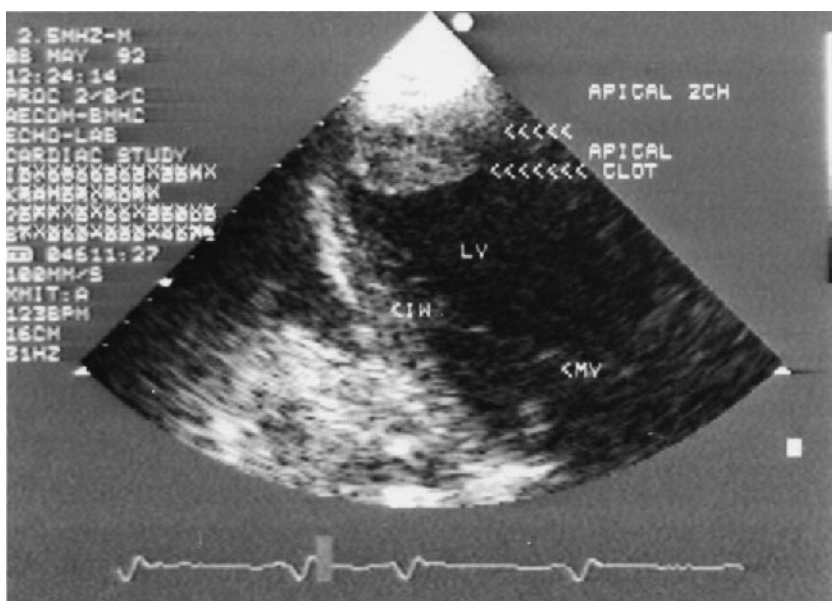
Two-dimensional apical two-chamber view in an elderly patient with dilated cardiomyopathy shows a large apical thrombus. LV = left ventricle; IW = inferior wall; MV = mitral valve.
